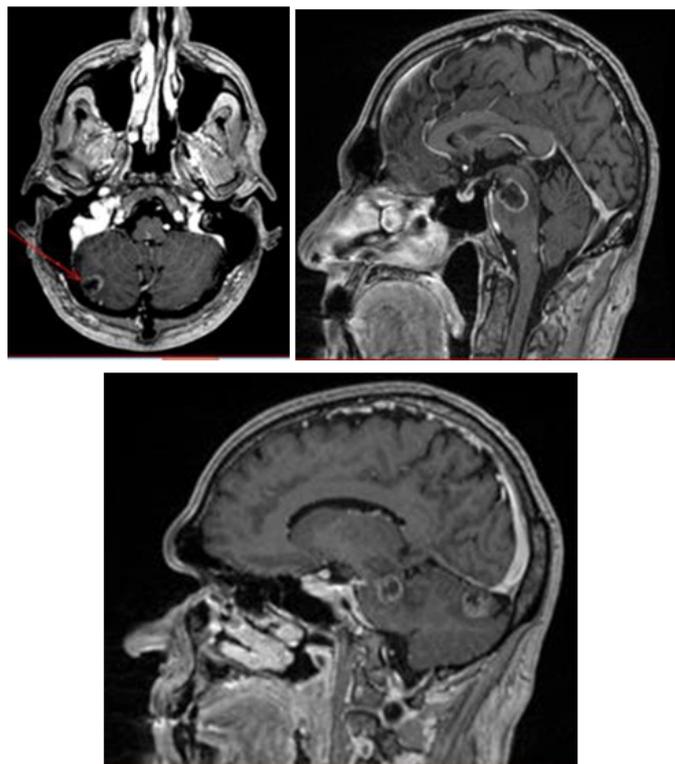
Magnetic resonance images of metastatic lesions in the brainstem and cerebellum. Image (A) is a sagittal T1 post gadolinium sequence demonstrating a 2.3 cm rim enhancing lesion in the pons and mid-brain. Image (B) is an axial T1 post gadolinium sequence showing a 1.3 cm rim enhancing lesion of the cerebellum. Image (C) is a sagittal T1 post gadolinium sequence of an additional cerebellar lesion and a portion of the mid-brain lesion.
